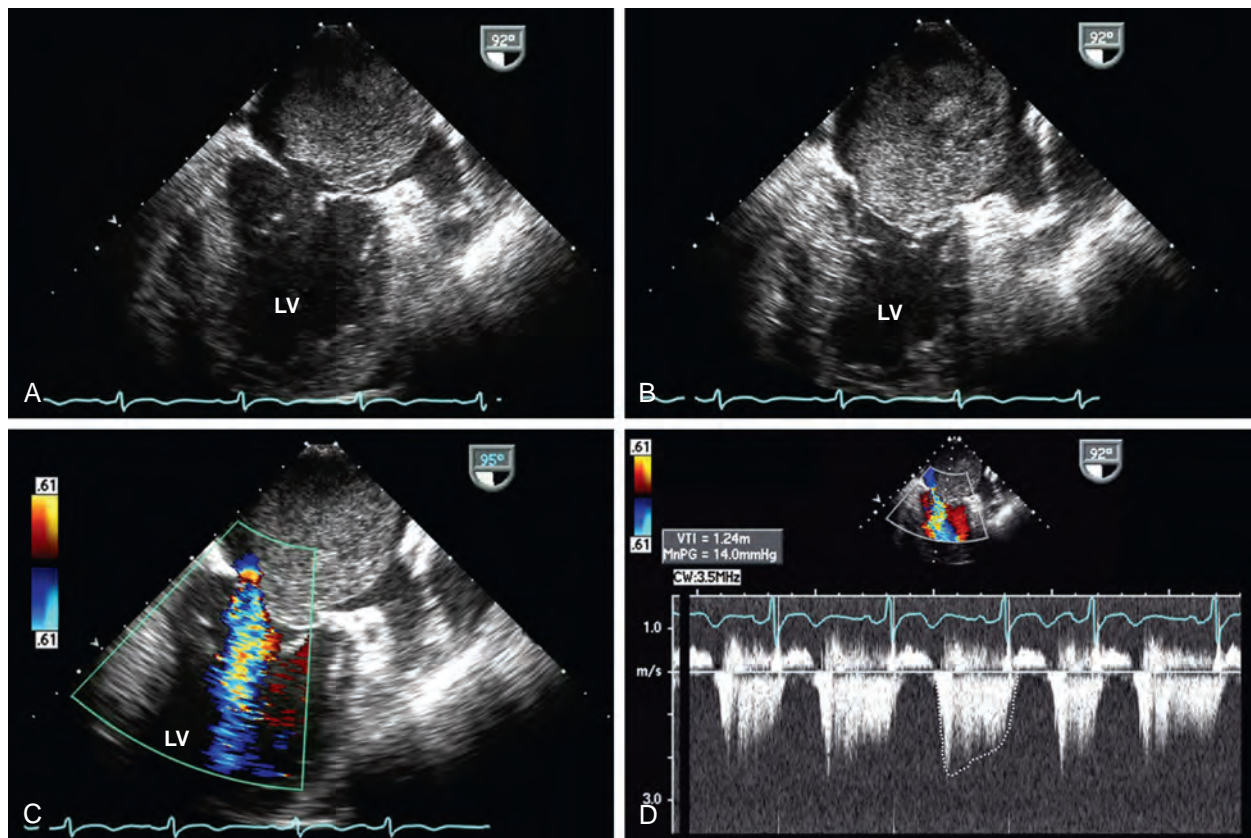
Transesophageal echocardiographic characteristics of a large left atrial myxoma. (A) Midesophageal two-chamber view during systole shows a 5 × 7 cm mass located in the left atrium. (B) Two-dimensional and (C) color-flow Doppler images show that during diastole, the mass obstructs flow across the mitral valve, creating severe functional mitral stenosis. (D) Continuous-wave Doppler across the mitral valve demonstrates a mean gradient of 14 mm Hg. LV, Left ventricle. (Reproduced with permission from Otto CM, ed. *Practice of Clinical Echocardiography*. 4th ed. Philadelphia: Saunders/Elsevier; 2012.)
